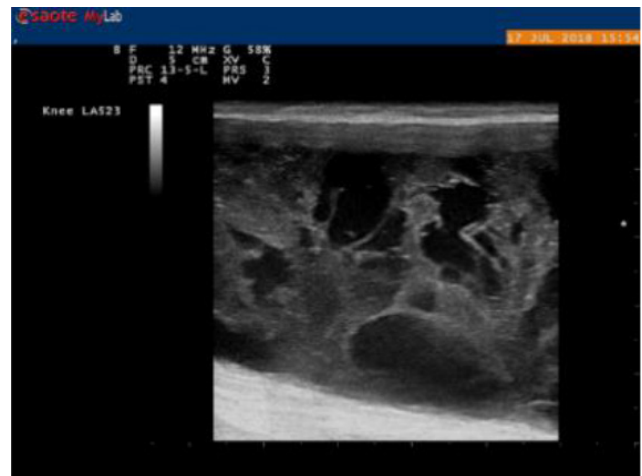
Ultrasound of the knee and synovial proliferation.
